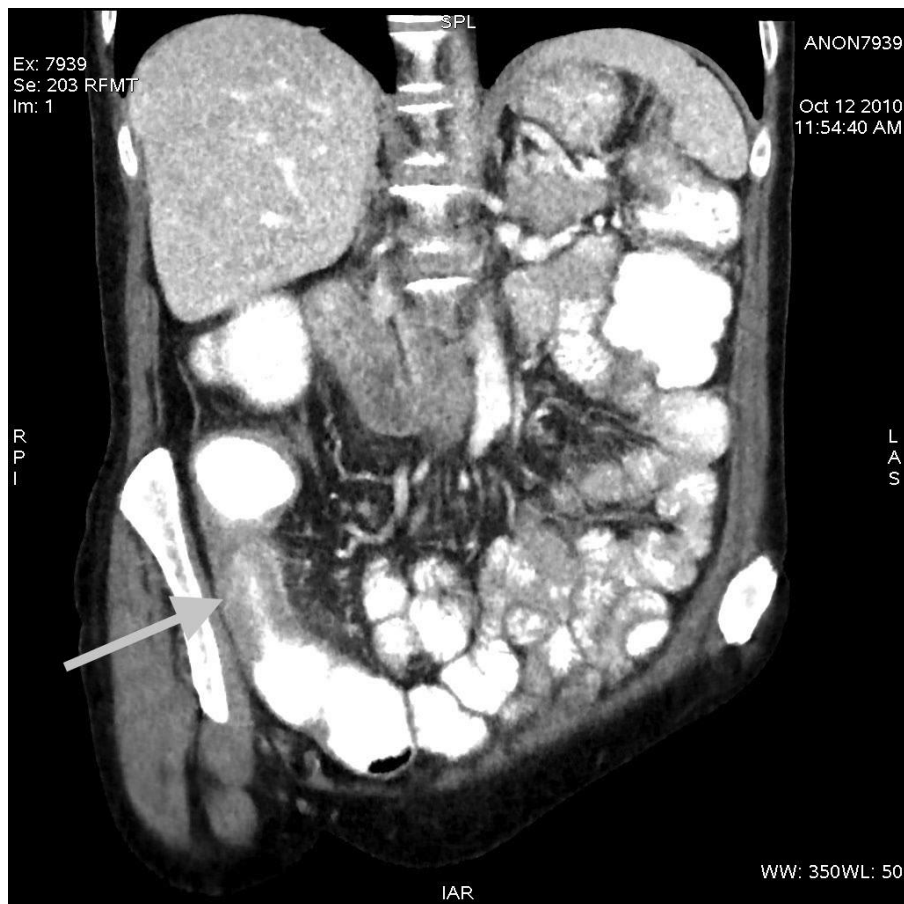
Coronal reconstruction of modified dose CT of the abdomen and pelvis with MBIR of a 59 year old lady with a BMI of 17.4 kg/m². The arrow points to a segment of mural thickening of the distal ileum with local mesenteric injection in keeping with acute enteritis. In this case the segment is more focal with proximal bowel dilatation suggesting a non-obstructing stricture. This CT study was acquired with a radiation dose of 0.65mSv.
